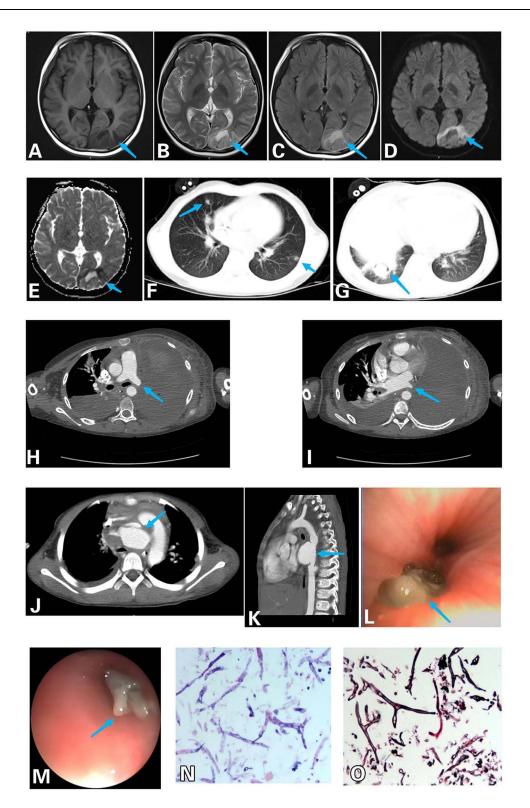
Figure I (A–E) Magnetic resonance imaging of patient No. 2. (A) The left occipital lobe showed an irregular gyrus with an abnormal signal shadow and a low signal on TIWI (arrow). (B) Slightly high signal on T2WI (arrow). (C) Slightly high signal on FLAIR (arrow). (D) Limited DWI diffusion (arrow). (E) Limited DWI diffusion (arrow). (F) Computed tomography (CT) of patient No. 1 showing multiple pulmonary nodules and marginal halo sign (arrow). (G) Computed tomography (CT) of patient No. 1 showing air crescent sign (arrow). (H) Enhanced CT of patient No. 3 showing left pulmonary artery occlusion, left atelectasis and left pleural effusion (arrow). (I) Enhanced CT of patient No. 3 showing left pulmonary vein occlusion (arrow). (J) Enhanced CT of patient No. 1 showing aortic arch dissection with ruptured pseudoaneurysm (arrow). (K) Enhanced CT of patient No. 4 showing a pseudoaneurysm of the descending aorta (arrow). (L) Bronchoscope of patient No. 4 showing a grayish-brown necrotic mass occluding the middle lobe of the right lung (arrow). (M) Bronchoscope of patient No. 1 showing a gelatinous substance occluded the base lobe of the left lower lung (arrow). (N) Alveolar lavage fluid pathology of patient No. 3 showing typical hyphal morphology. *Mucorales* hyphae were at least 6–16 µm wide, ribbon-like, pauci-septate, with subrectangular branching (PASM 20X).
